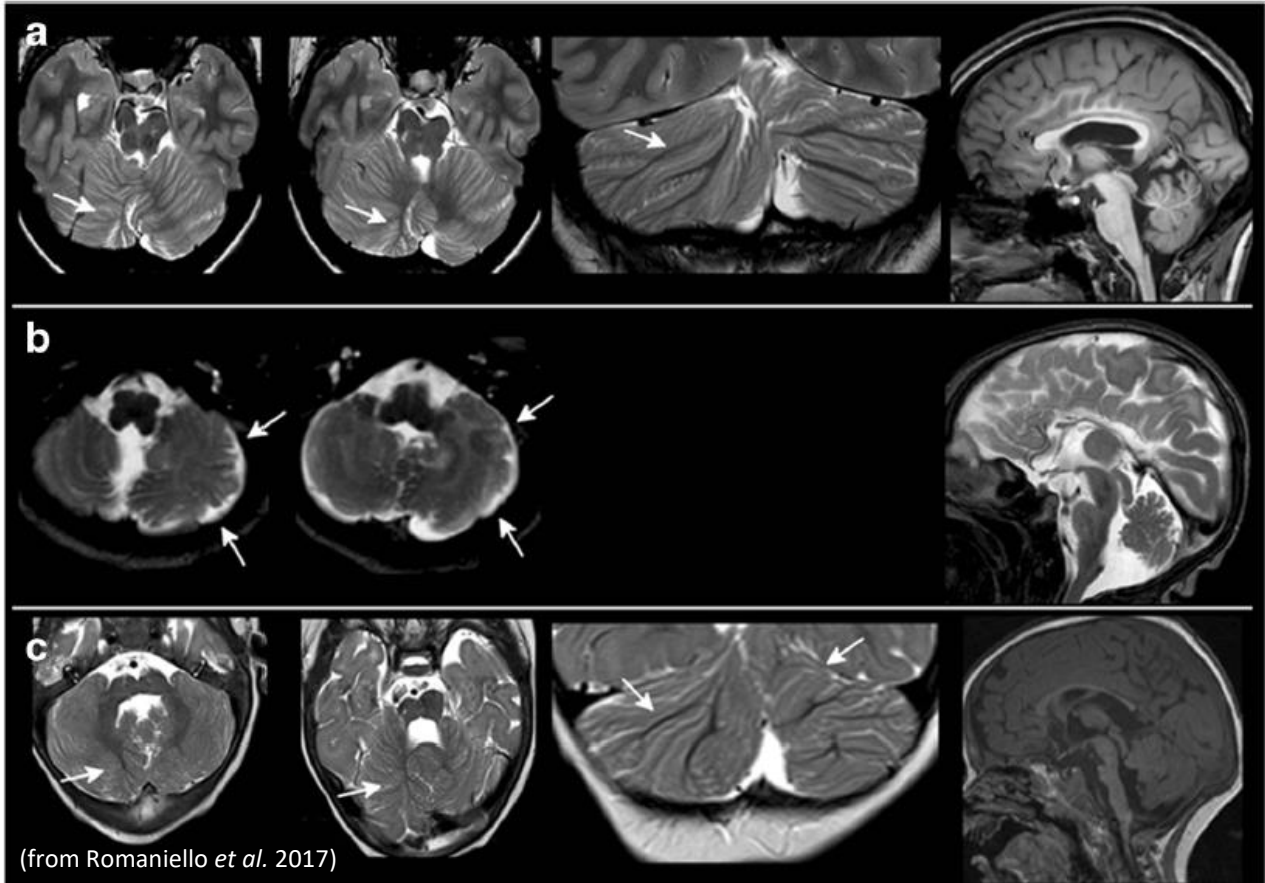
MRI findings in patients with mutations in TUBA1A gene. Representative MRI findings from three patients. (A) Irregular orientation of cerebellar folia in the right hemisphere and dysplastic vermian (B) Severe dysplasia of the left cerebellar hemisphere and vermian hypoplasia (C) Involvement of the right and the posterior left hemispheres and pontine hypoplasia. In all three patients, corpus callosus anomalies are also evident on sagittal planes.
